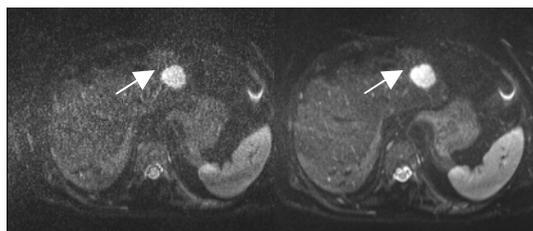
Patient with hemangioma in left lobe of the liver seen with BH (left) and NBH DWI (right) at b0 (arrow). The NBH image show better image quality, and better lesion conspicuity than BH image.
